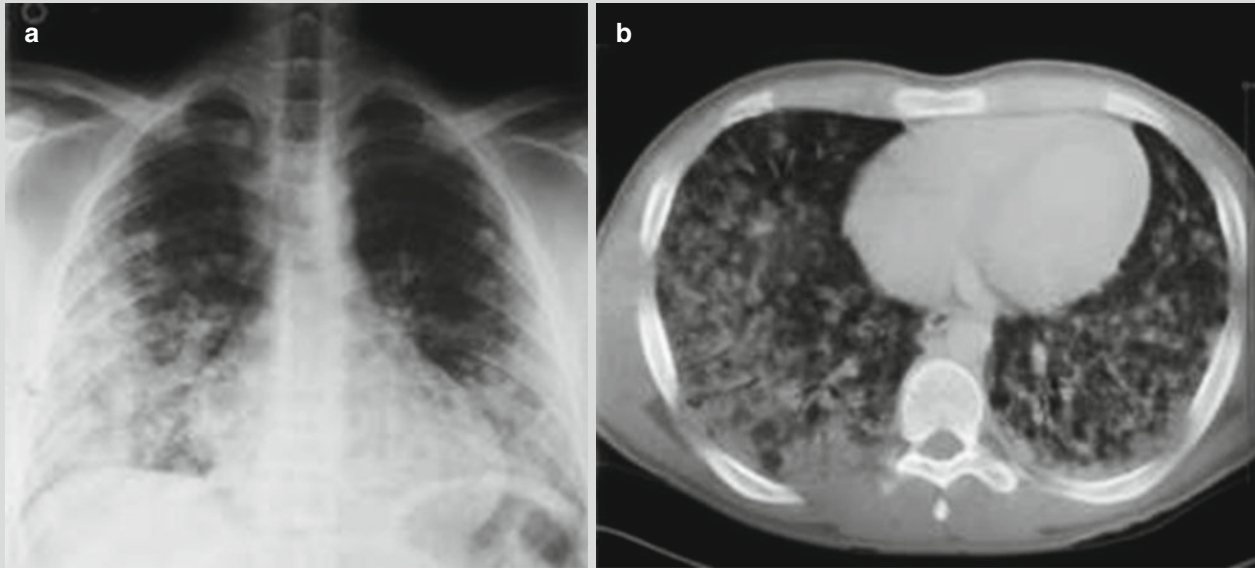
Leptospirosis with pulmonary bleeding. (a) X-ray demonstrates patches of blurry shadows in bilateral middle and lower lung fields. (b) CT scanning demonstrates alveoli and interstitium
